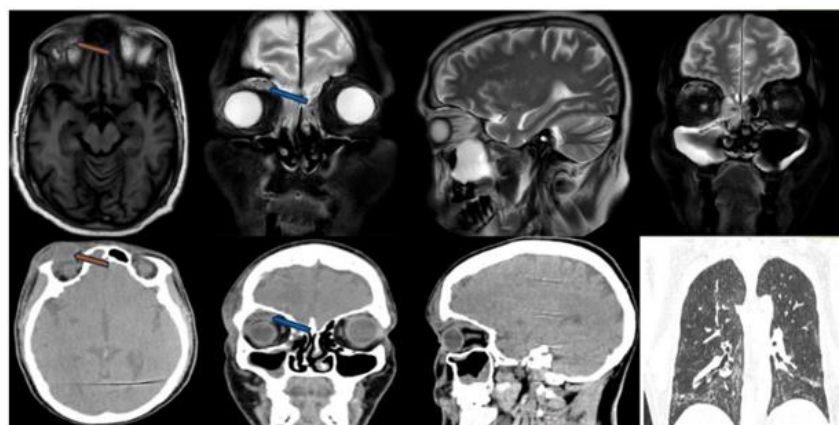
Plain CT showing ill-defined hypodense extraconal collection along roof of right orbit (orange arrow). T1W, T2W and FS images showing ill-defined collection around superior rectus muscle (blue arrow) with fat stranding. There is mucosal thickening in right maxillary sinus. HRCT chest showing patchy GGOs with fibrotic opacity. S/O orbital cellulitis with COVID-19 sequelae.
